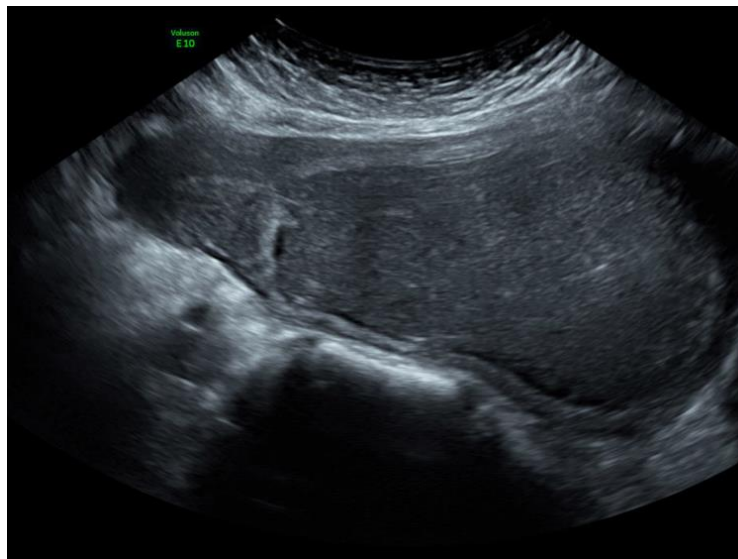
Ultrasound image of the hematocolpos.
